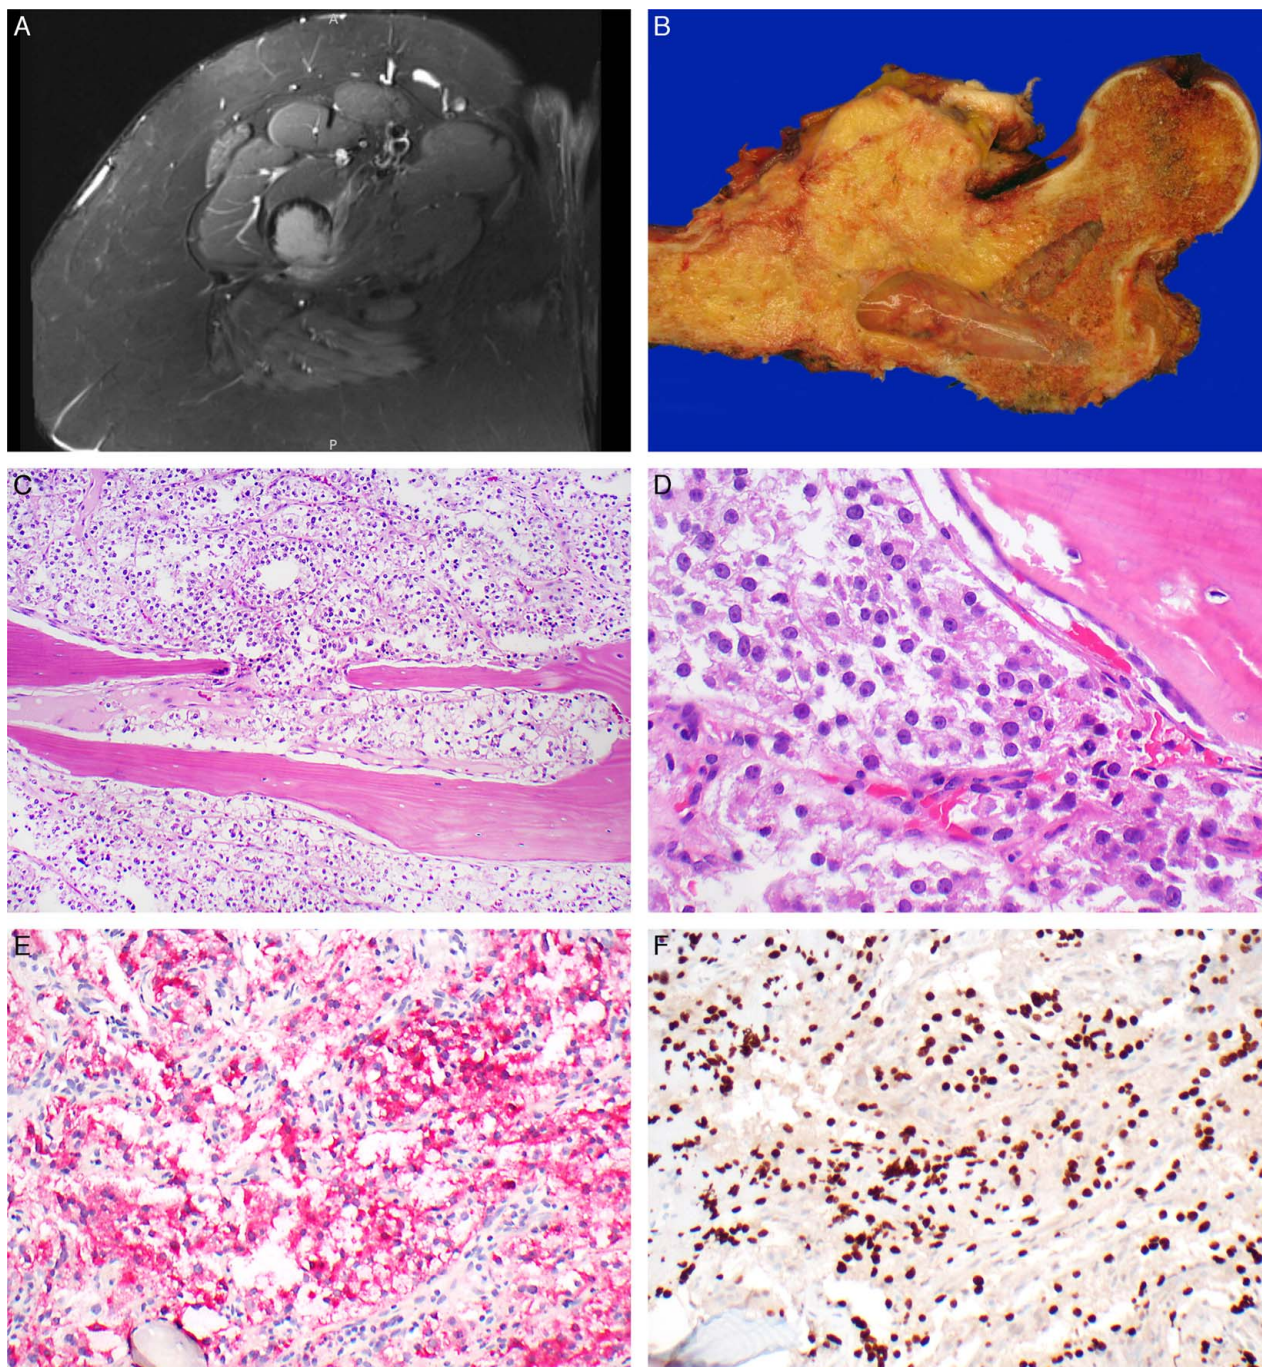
(case 2): MRI STIR images reveal an aggressive lesion in the proximal femur showing cortical breakthrough and extension into adjacent soft tissue (A). On gross examination, the fleshy tumor involves the femoral neck and breaks through the cortex to extend into soft tissue. Defects consistent with prior rod placement are also evident (B). The epithelioid neoplastic cells are arranged in nests, and permeate into existing lamellar bony trabeculae (C). At high power, the neoplastic cells about bone lined by osteoblasts. The neoplastic cells have round nuclei with pinpoint nucleoli and granular eosinophilic to pale cytoplasm (D). The neoplastic cells demonstrate diffuse cytoplasmic labeling for HMB45 (red chromogen, E) and diffuse strong nuclear labeling for TFE3 (F).
